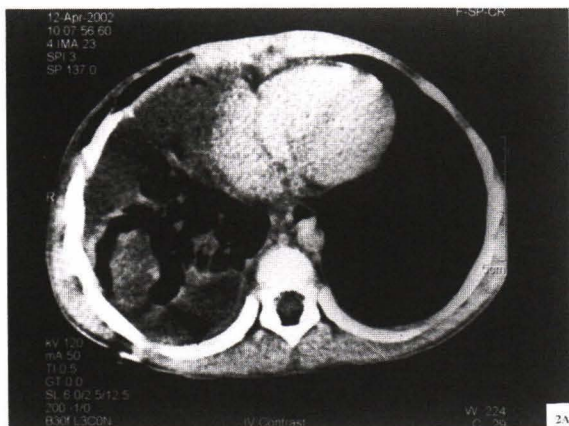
Computed tomography of the chest reveals a cavity with an intramural mass confined in the right lower lobe accompanied with hydropneumothorax (A: axial, B: coronal multiplanar reconstruction).
